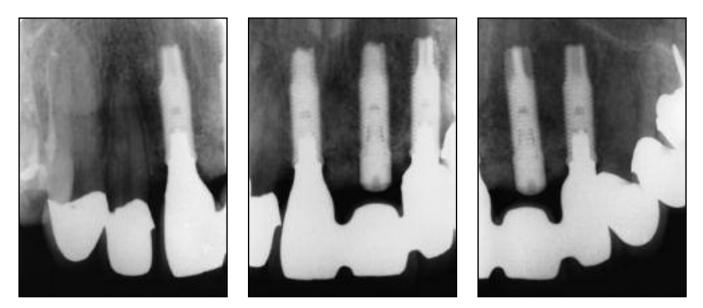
Periapical radiograph taken 2 years after the implants became functional. Regenerated tissue height was preserved by using a strategically placed pontic instead of all three neighboring implants. Platform switching seems to have had a positive effect on the bone preservation around the functioning implants.
